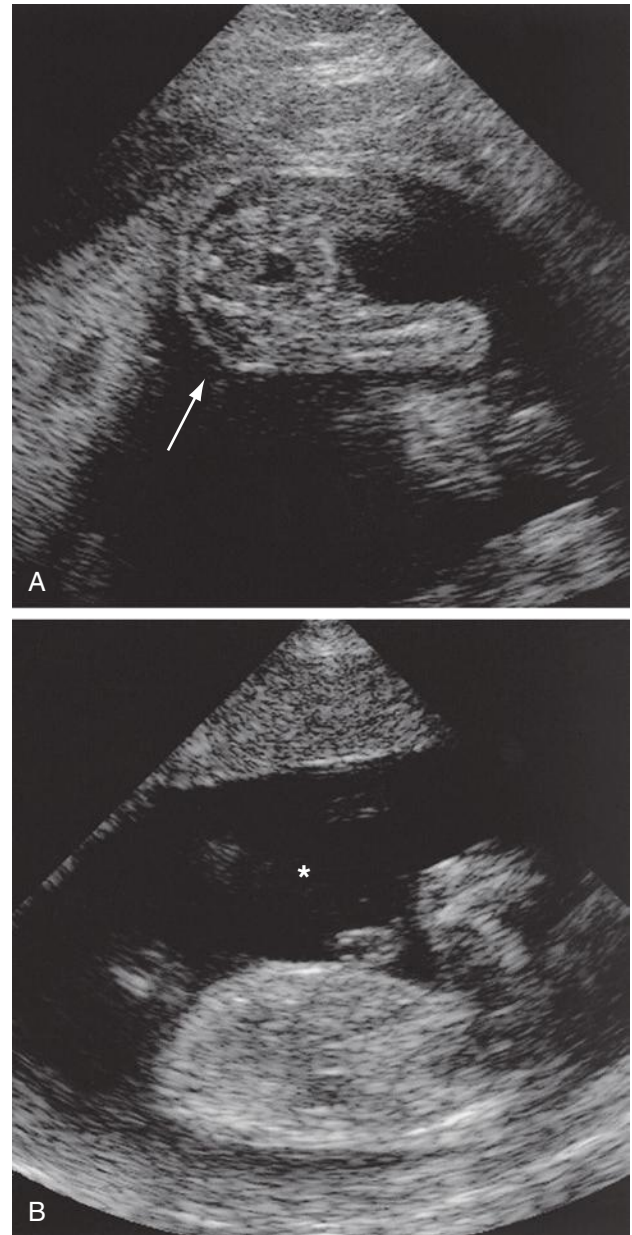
Sonogram of a patient with a monochorionic twin pregnancy with twin-to-twin transfusion syndrome. A, The donor fetus in the oligohydramniotic sac (arrow) is “stuck” to the anterior uterine wall. B, The recipient fetus is in a polyhydramniotic sac (asterisk). Often the dividing amniotic membrane cannot be identified.
